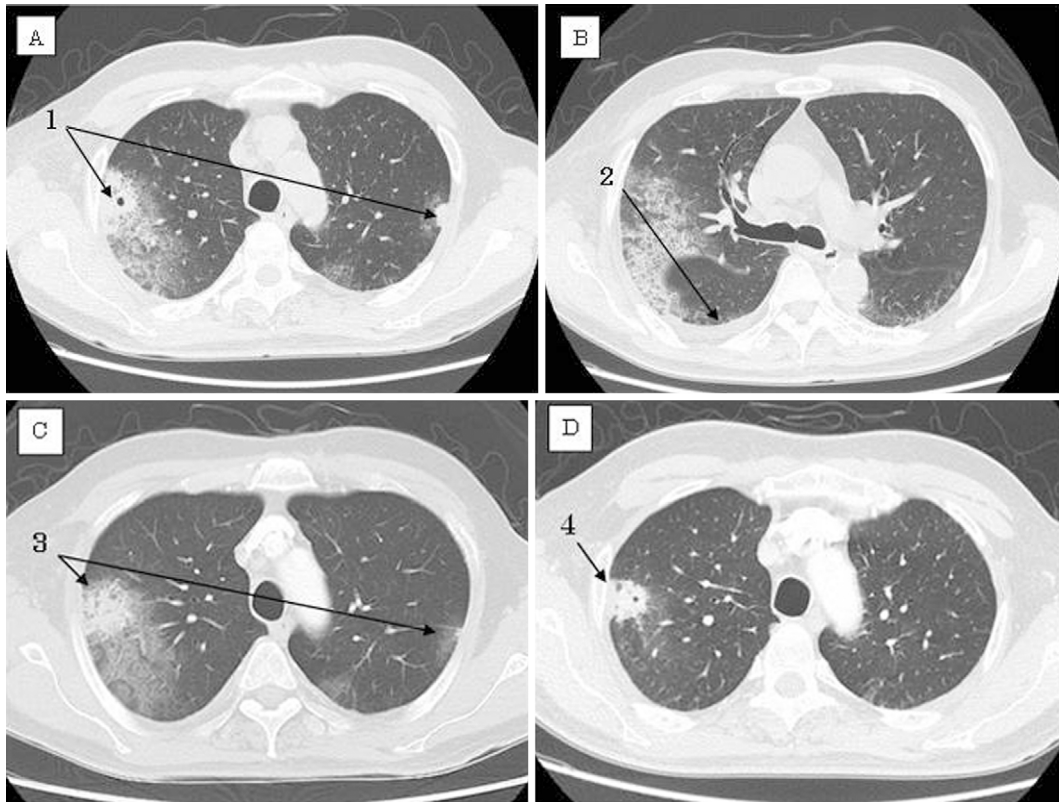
The port catheter was removed at day 8 of 4th ABVd chemotherapy. Nevertheless, he represented continuous fever accompanied by dry cough and chest pain. The occurrence of SPE was diagnosed by chest-CT. During the course of therapies of antibiotics and anti-coagulants, his symptoms and values for serum CRP and D-dimer were markedly improved in parallel with the amelioration of pulmonary radiographic imaging.
